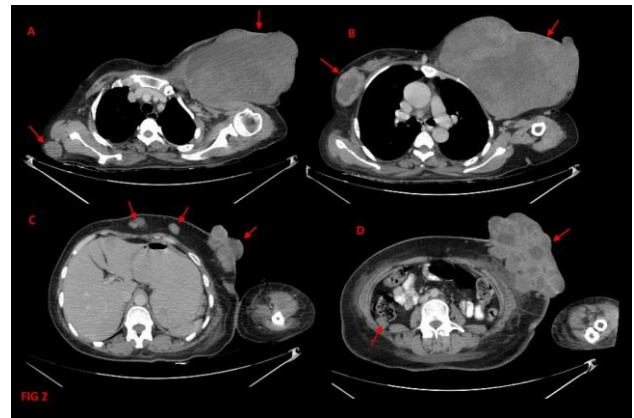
Axial contrast CT showing peripheral nodular enhancement of the lesions (arrows).
